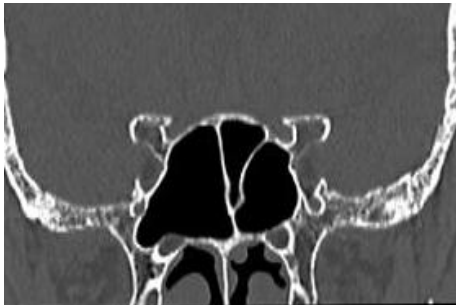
Coronal CT scan showing the accessory septa in left sphenoid sinus attaching to ipsilateral optic canal.
